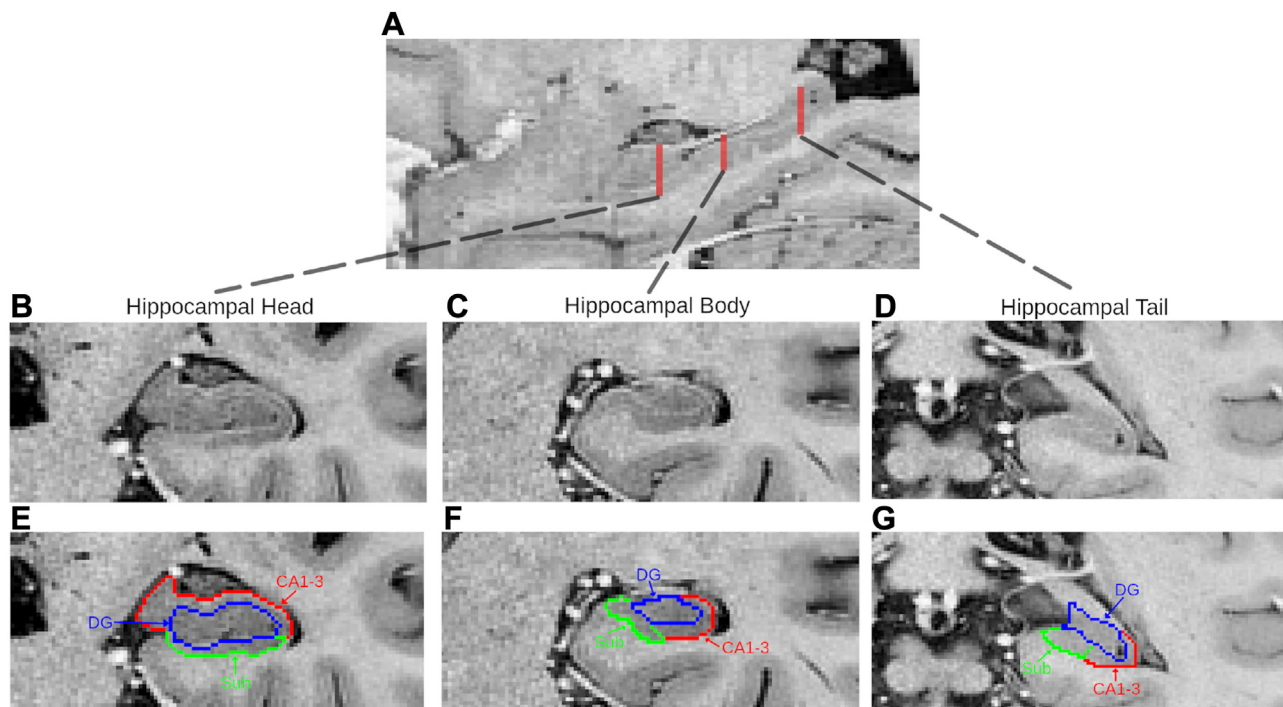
Segmentation of the hippocampal subfields within anteroposterior hippocampal subregions (A–D) is shown on T2-weighted fast spin echo images with inverted contrast: coronal views of the hippocampal head (B), hippocampal body (C), and hippocampal tail (D). Cornu ammonis 1–3 (CA1–3) is shown in red, dentate gyrus (DG) is shown in blue, and subiculum (Sub) is shown in green.
